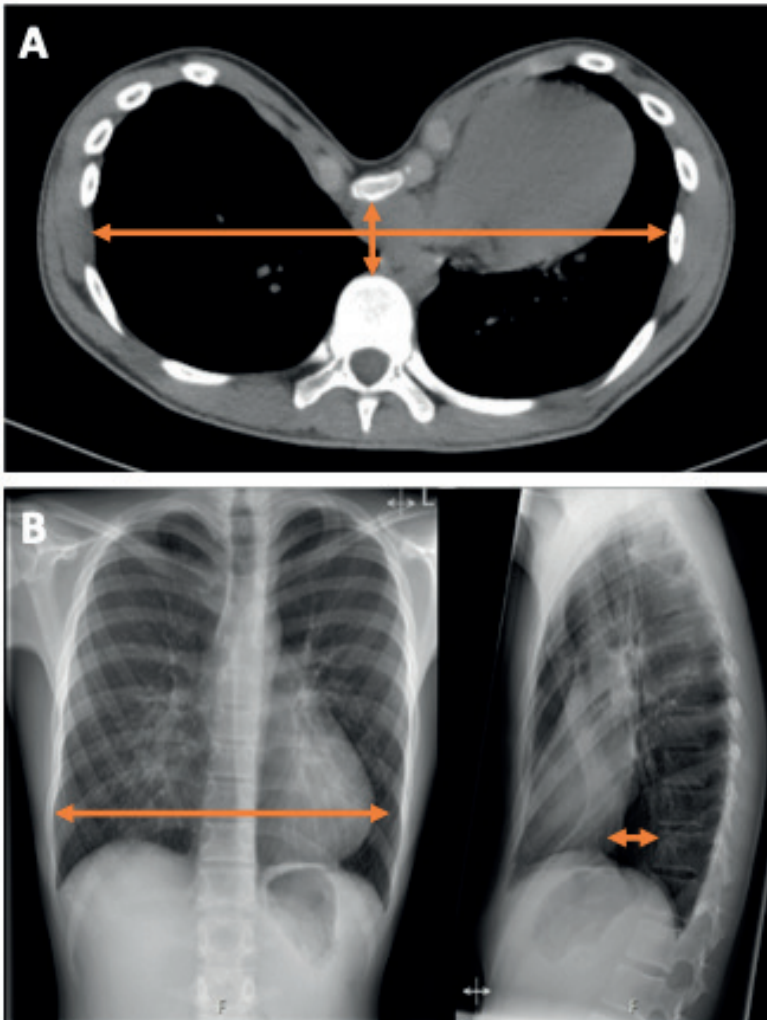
Haller index. The Haller index: calculated from either (A) computed tomography or (B) 2-view plain chest radiographies by dividing the widest intrathoracic transverse diameter by the anteroposterior distance between the posterior sternal surface and anterior vertebral surface at the level of most severe depression. A Haller index value larger than or equal to 3.25 is considered as indication for corrective surgery [E1].
